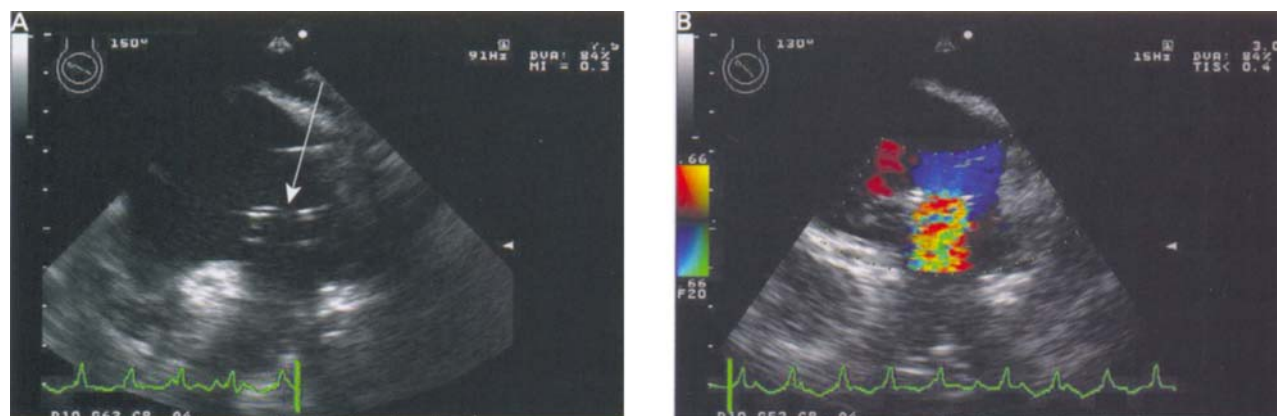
Right ventricular assist device (RVAD) inflow cannula placed through the right atrial appendage, visible in the (A) mid-oesophageal bicaval view (arrow). (B) Colour flow Doppler shows laminar flow toward the cannula and flow mosaic in the cannula entrance.
